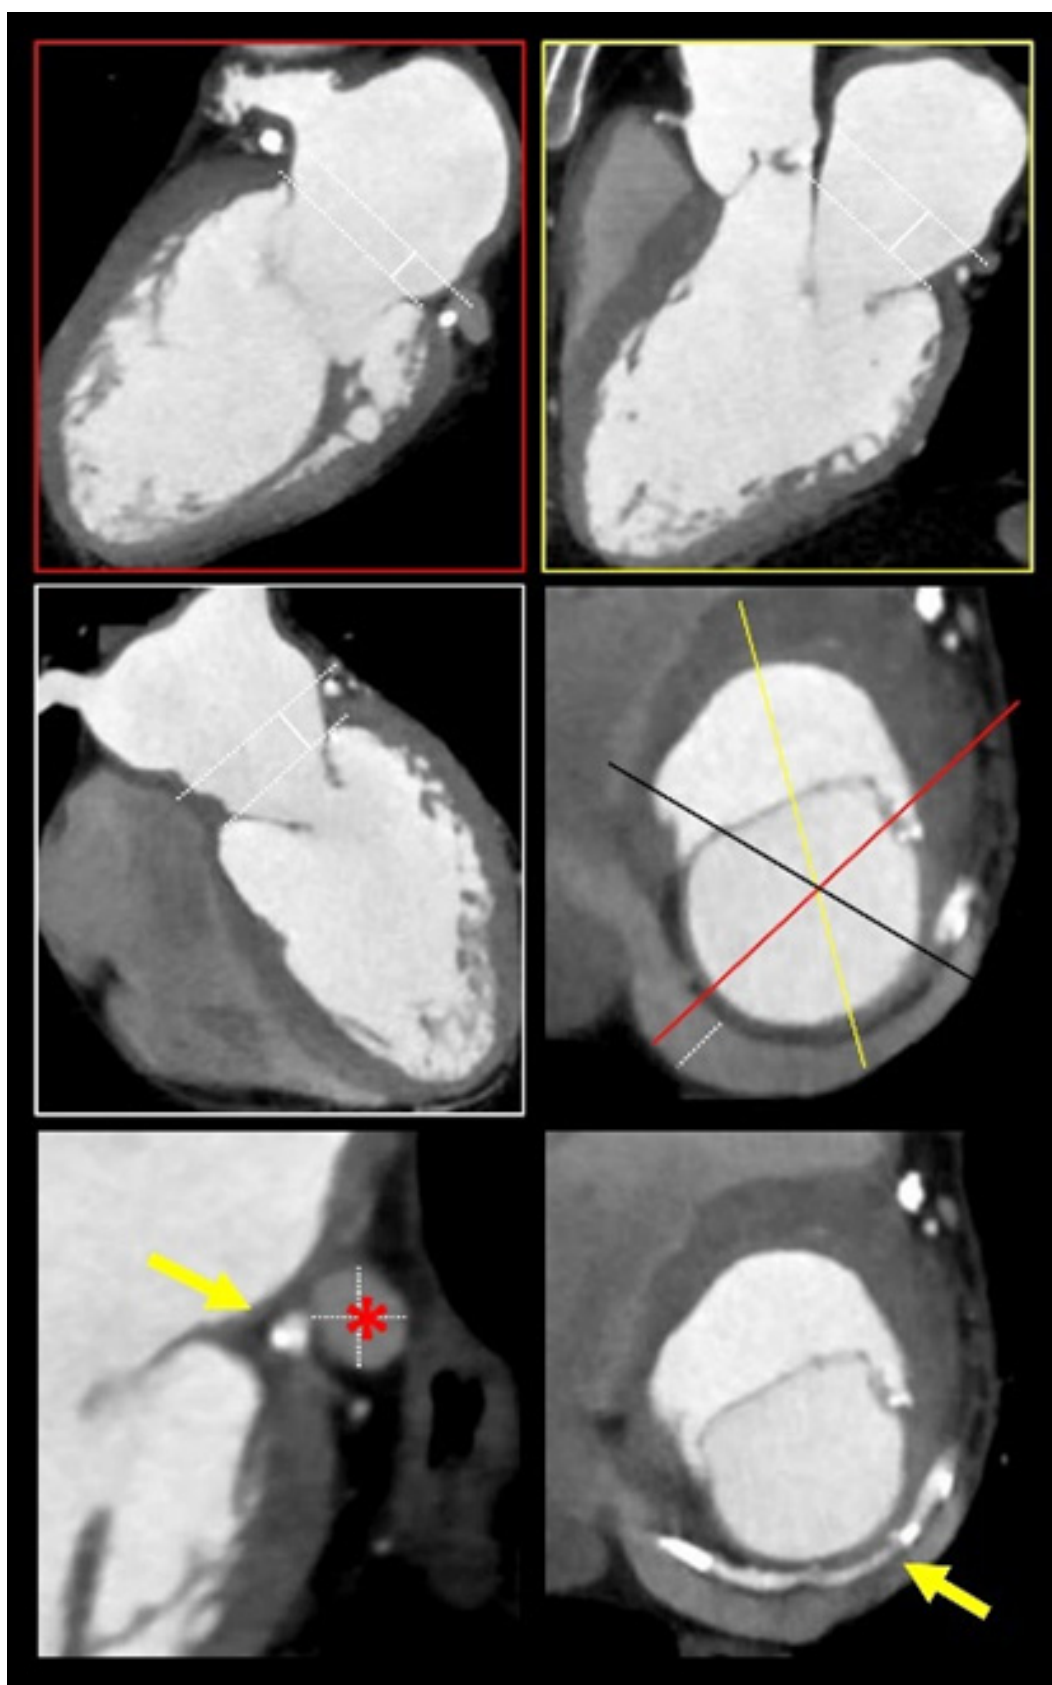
CT preprocedural planning for indirect annuloplasty showing spatial relationship of the coronary sinus with respect to the mitral annulus plane and the LCX (yellow arrow) and CS (red asterisk). LCX: left circumflex artery; CS: coronary sinus
